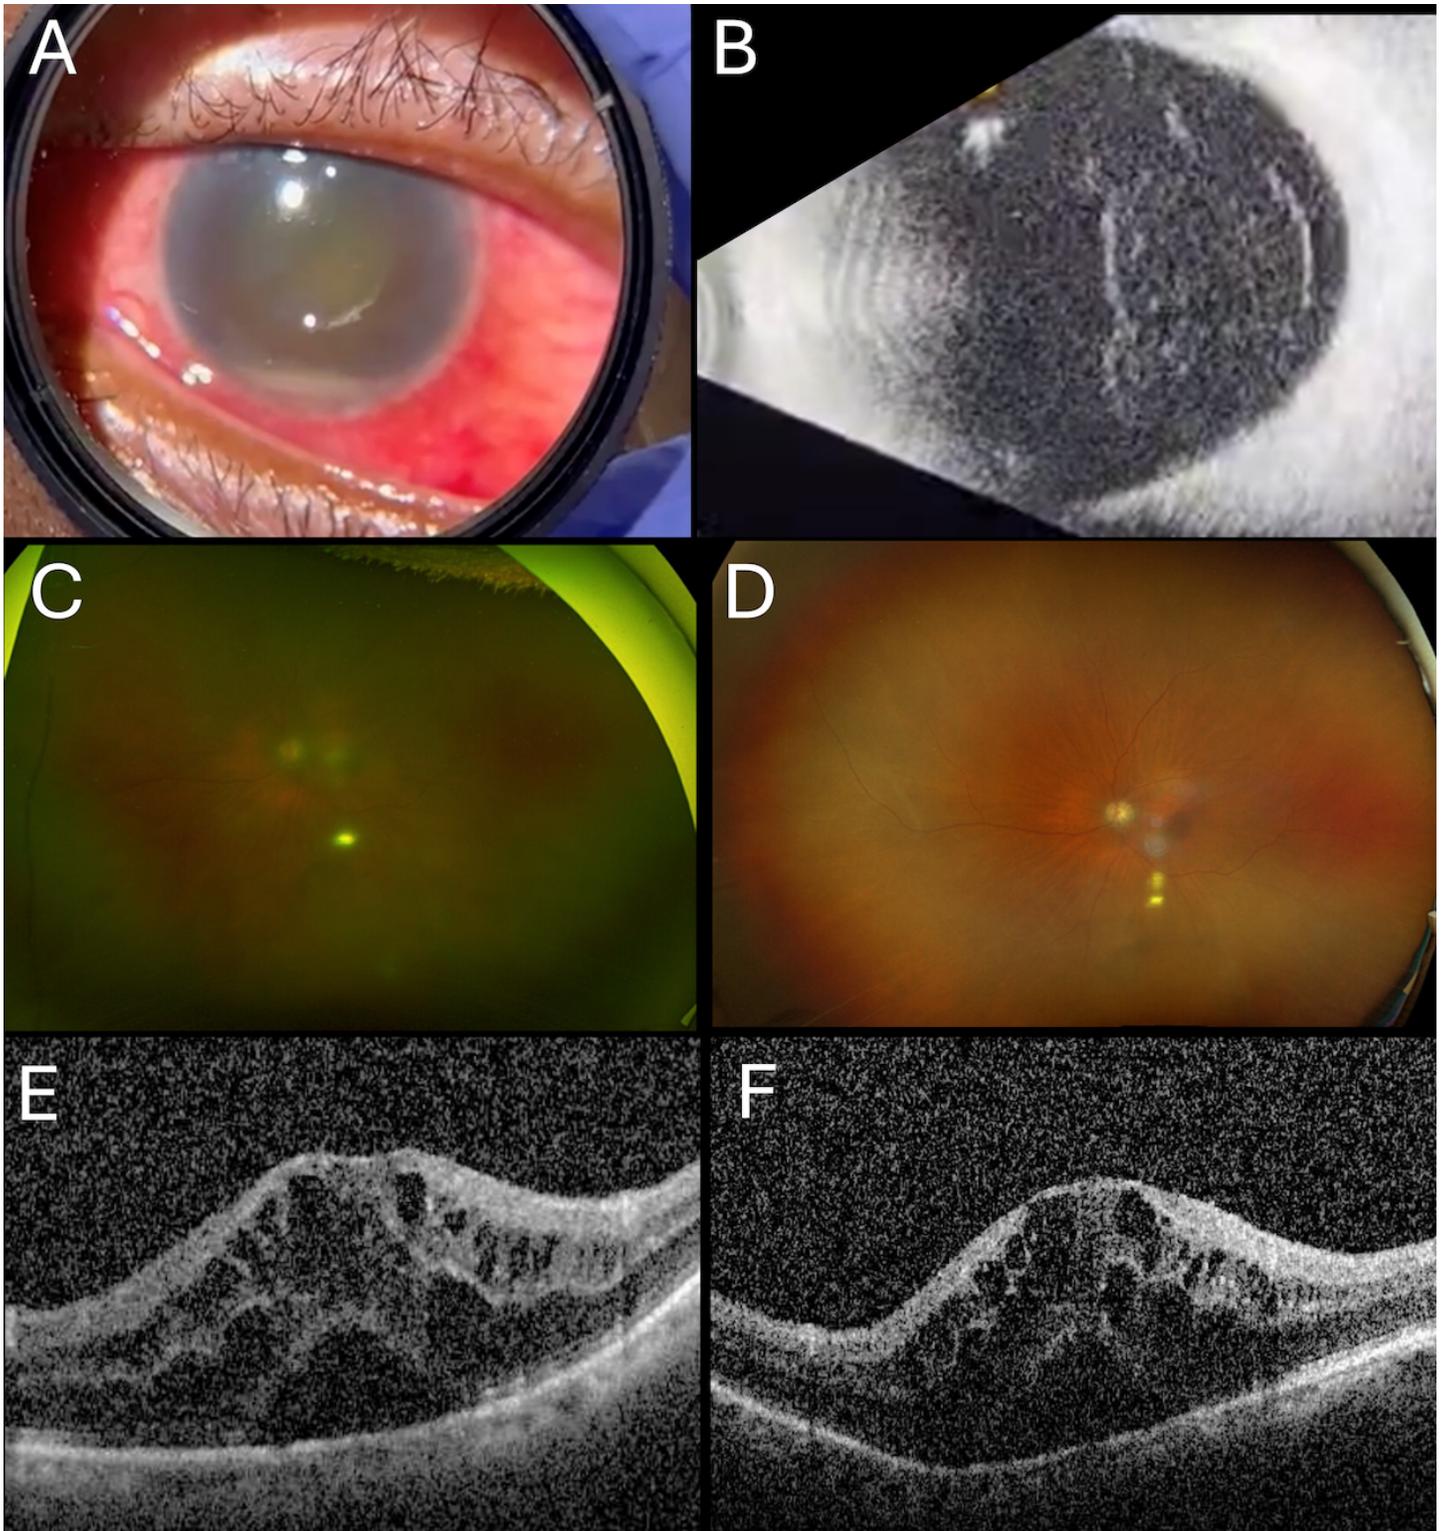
A. Magnified anterior view of the left eye at presentation was notable for diffuse conjunctival injection, diffuse corneal edema, and a layering hypopyon, B. B-scan ultrasonography of the left eye on presentation demonstrated moderate vitreous opacities, C. Ultra-widefield fundus photo of the left eye at 2-week follow-up demonstrated an improved, albeit still hazy, view secondary to vitritis and no apparent retinal lesions, D. Fundus photo of the left eye at 3 weeks revealed significantly improved vitritis and no retinal lesions, E. Optical coherence tomography (OCT) at the 2 month follow-up revealed new cystoid macular edema
